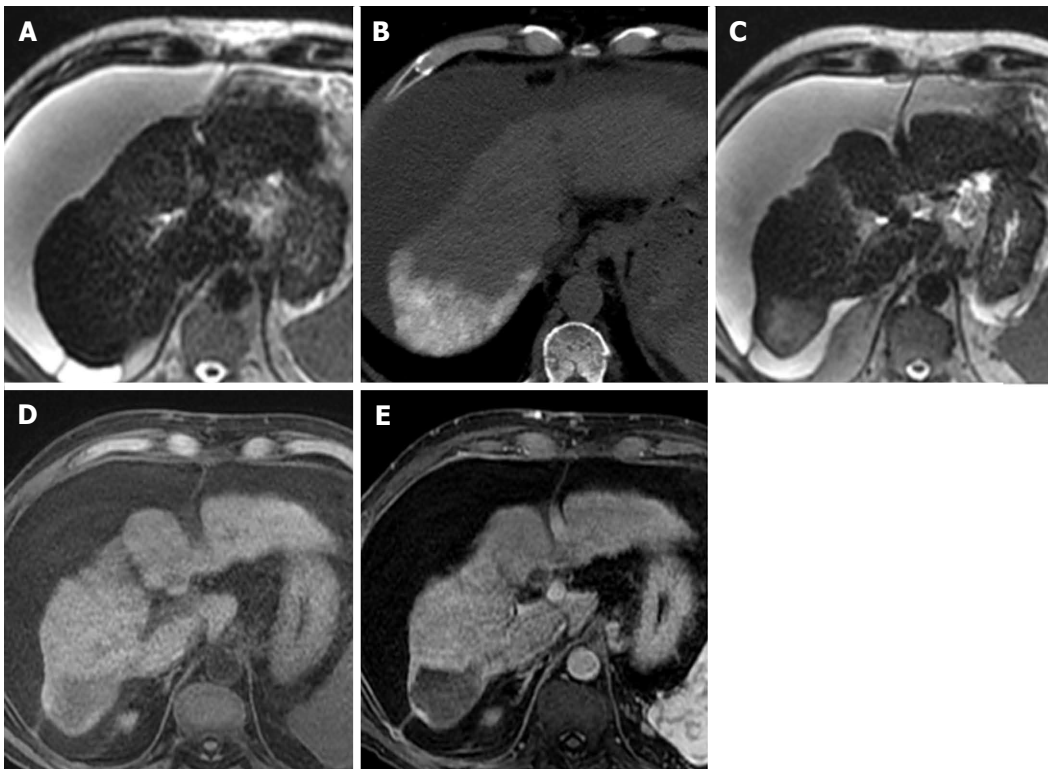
Treatment-related signal alterations on T2-weighted images. A 63-year-old man with HCV/EtOH cirrhosis and a segment VII LI-RADS 5B lesion measuring 2.4 cm × 1.8 cm. T2-weighted image (A) just superior to the segment VI lesion before treatment demonstrates a cirrhotic liver with homogeneous low signal intensity. Non-contrast CT (B) performed immediately after a TACE procedure shows high attenuation Lipiodol® in segment VII confirming that the appropriate segment was treated. T2-weighted image (C) from an MRI performed one month later shows high signal intensity in the area that was treated due to fibrotic change. Precontrast (D) and arterial-phase images (E) from that exam demonstrate that the treated area is completely necrotic. LI-RADS: Liver imaging reporting and data system; TACE: Transarterial chemoembolization; HCV: Hepatitis C virus; CT: Computed tomography; MRI: Magnetic resonance imaging.
